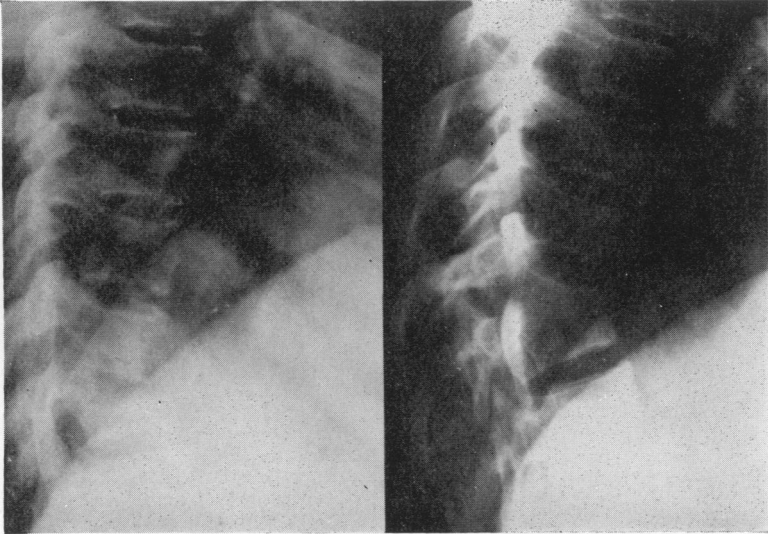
X-rays showing a good result from the treatment of spinal tuberculosis with drugs.
